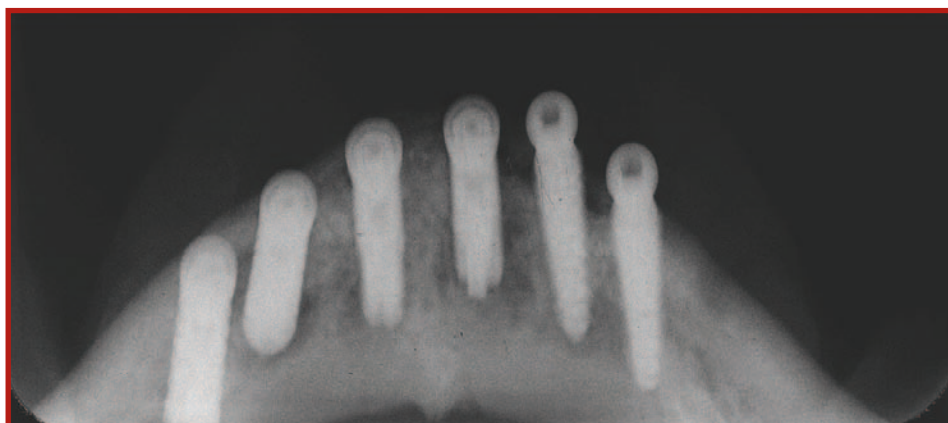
Post-operative mandibular occlusal radiograph after implant placement showing ill defined radiolucent areas around all the implants.
